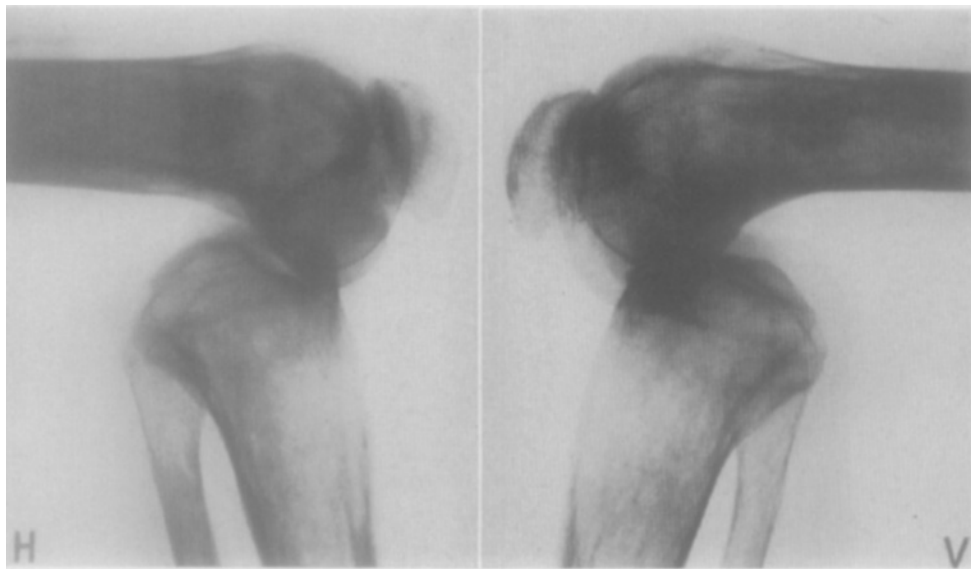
Case 8: roentgenograms of right and left knee before operation.
